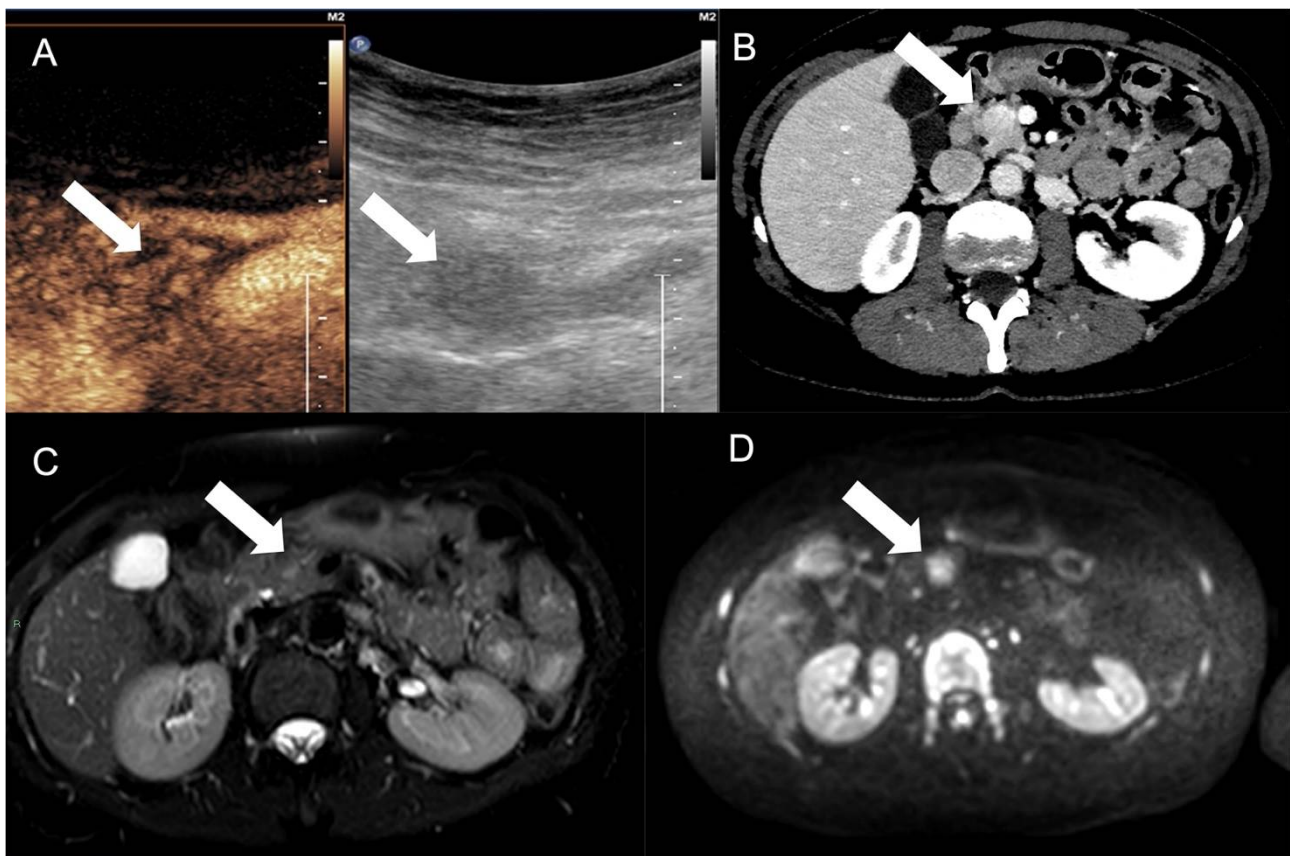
A pancreatic NEN tumor (arrow) was discovered as hypoechoic mass at ultrasound, showing high vascularization at CEUS (A) and CT (B). At MRI examination, the mass was not clearly defined with T2W fat-suppression sequence (C), while the restriction at diffusion imaging improved the definition of the mass (D).
